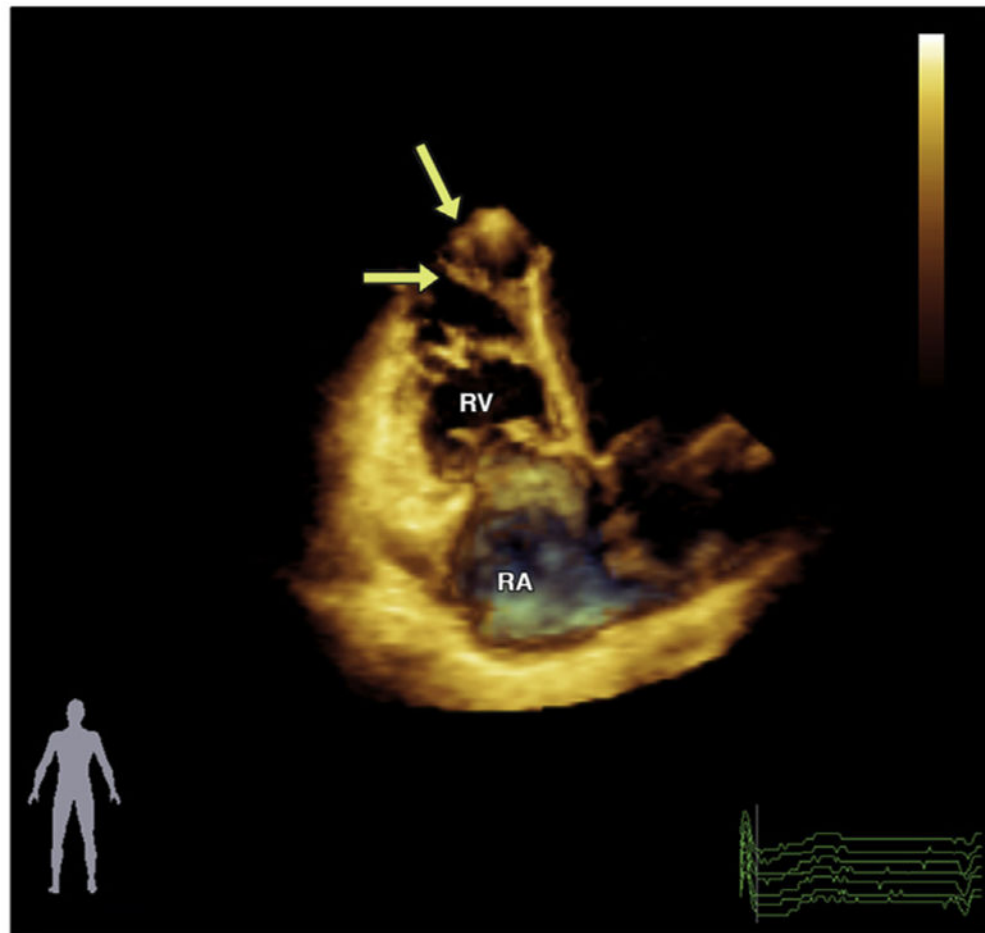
Three-Dimensional Echocardiography in the Apical View in a Patient With ARVD/C
